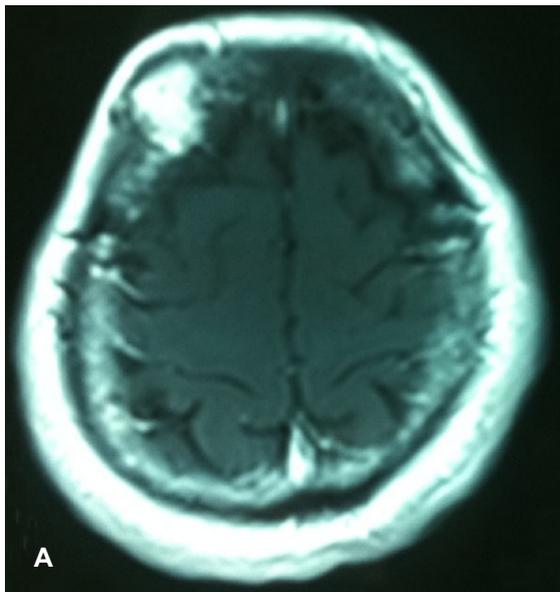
Axial CT image showing expansive and lytic lesions in the frontal and occipital bones.
